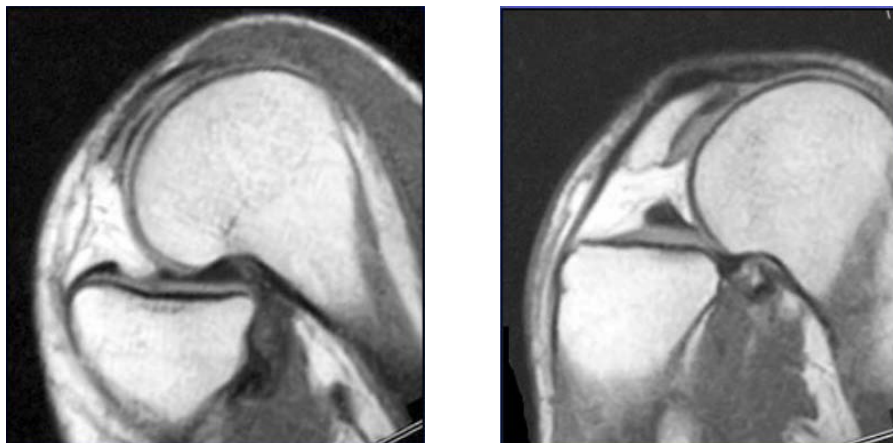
Two dynamic MRI Images demonstrating femoral roll back in deep flexion(⁶)
